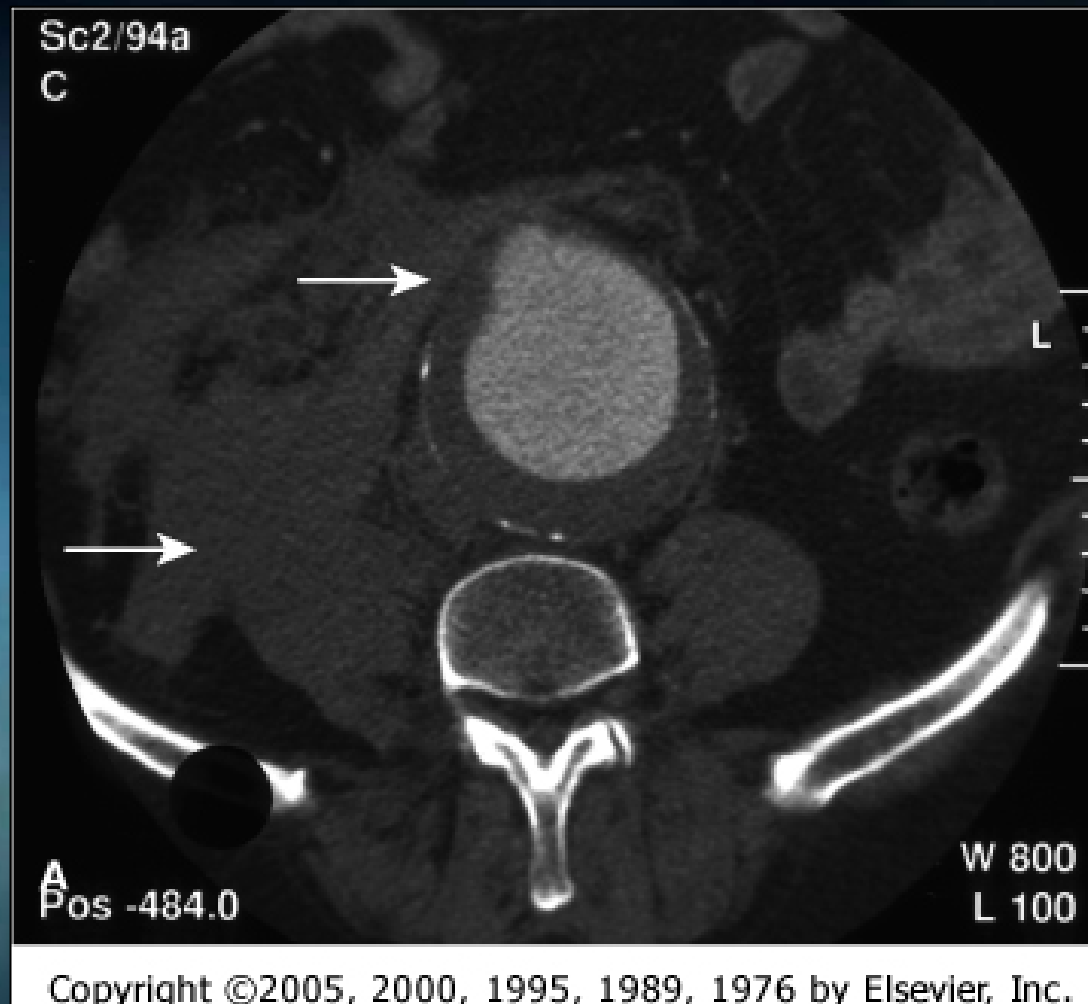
A, CT of ruptured AAA subsequently treated with endovascular aneurysm repair. Small arrow indicates site of rupture, and bold arrow indicates retroperitoneal hematoma. B, Postoperative angiogram after aorto-uni-iliac endografting and femorofemoral bypass.
